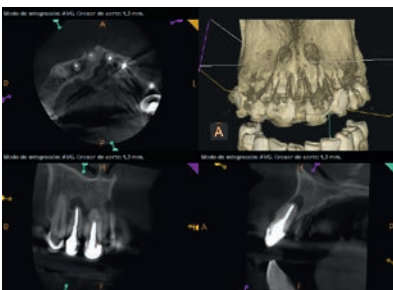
Upper right lateral incisor preoperative CBCT image.
